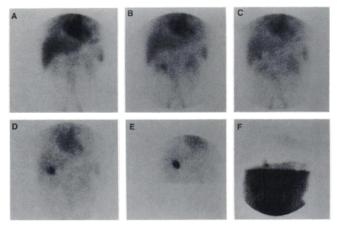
Technetium-99m-mebrofenin hepatobiliary scintigraphy (A) immediate, (B) 25 min, (C) 55 min, (D) 3 hr, (E) 6 hr and (F) 6 hr with lead shielding of the upper abdomen in order to demonstrate the presence of intestinal activity.
